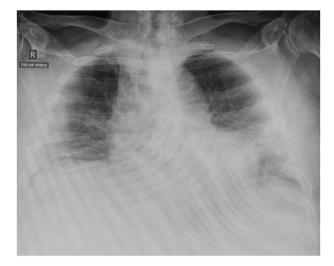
Patient chest X-ray at the end of COVID-19 hospitalization.
